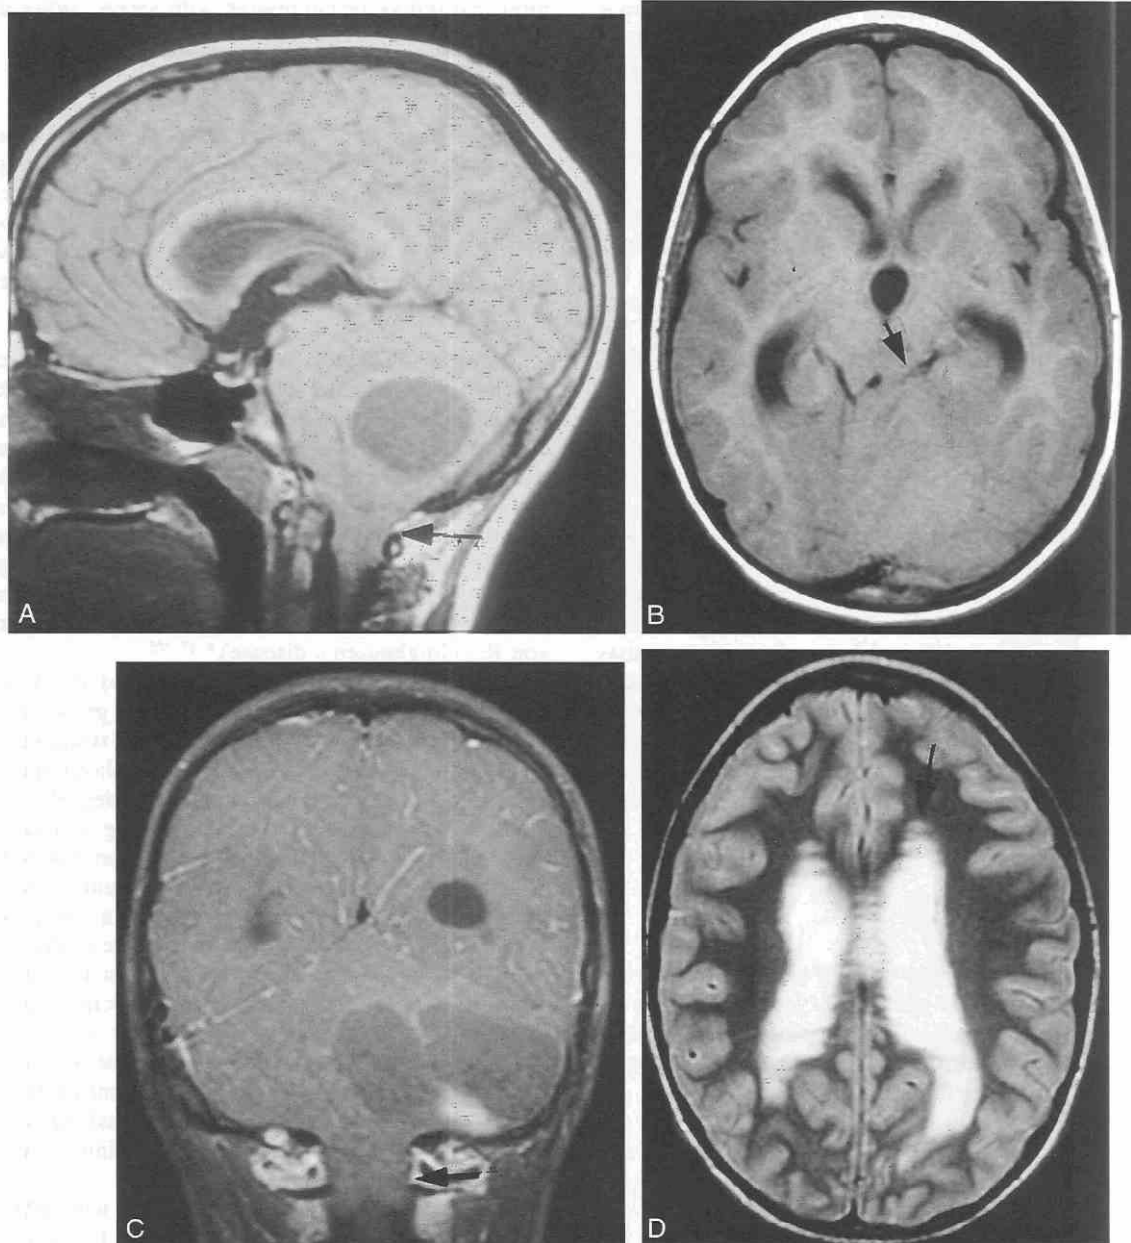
Juvenile pilocytic astrocytoma of the cerebellum causing interstitial edema and upward transtentorial herniation and tonsillar herniation. A, Left parasagittal T1-weighted MR image without intravenous contrast. A large sharply margined cyst in the left cerebellar hemisphere causes downward herniation of the cerebellar tonsils into the upper cervical spinal canal (*arrow*). The cystic mass compresses the fourth ventricle and pons from behind and displaces the superior vermis upward through the tentorial notch, obliterating the superior cerebellar and quadrigeminal cisterns and elevating and displacing forward the floor and posterior wall of the third ventricle. B, Axial T1-weighted noncontrast image at the level of the quadrigeminal cistern demonstrates forward displacement and compression of the quadrigeminal plate and cistern on the left (*arrow*) by the upwardly herniating superior cerebellar vermis and hemisphere. Note enlargement of the aqueduct, third ventricle, and temporal horns of the lateral ventricles secondary to obstruction of the fourth ventricle. C, Coronal T1-weighted image at the level of the posterior aspect of the foramen magnum following intravenous administration of gadolinium. Both cerebellar tonsils have herniated downward through the foramen magnum (*arrow*). Note homogeneous contrast enhancement of a solid tumor nodule in the floor of the left cerebellar hemisphere cystic mass. D, Axial T2-weighted image at the level of the superior aspect of the lateral ventricles. The ventricles are markedly distended, and cerebrospinal fluid has dissected across the ependymal margins of the ventricles into the adjacent periventricular white matter anteriorly (*arrow*) and in the corpus callosum.
